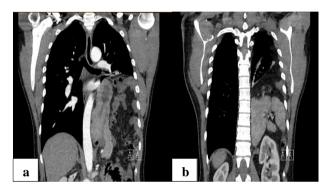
CT for pre-operative planning of large Bochdalek hernia containing omentum, stomach, left colon and some small bowel (jejunum) including mesentery, the superior pole of the left kidney, spleen, tail of pancreas, and with compression of the left lower lobe of lung and right cardiac displacement; (a) CT chest and (b) CT abdomen.
